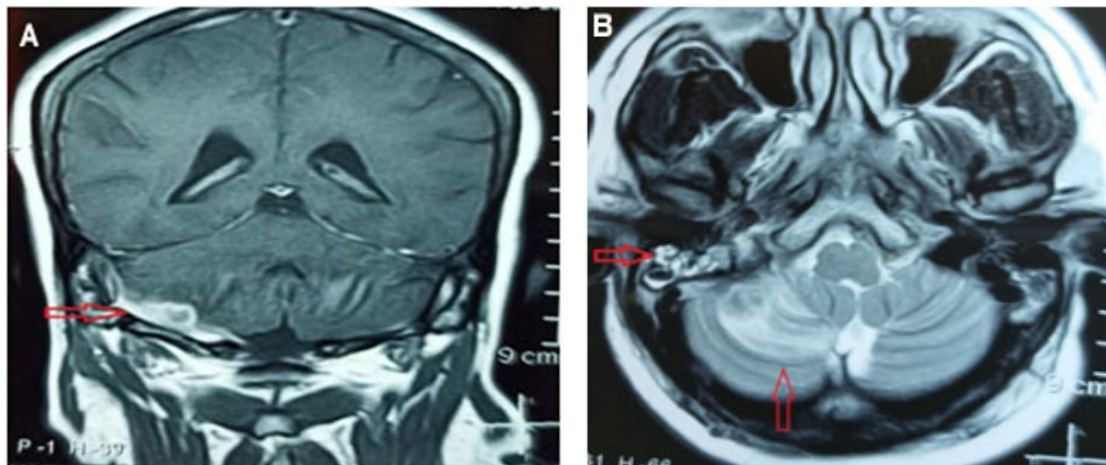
(A). Magnetic Resonance Imaging (MRI): Post-contrast T1 image (left) shows extradural abscess.
